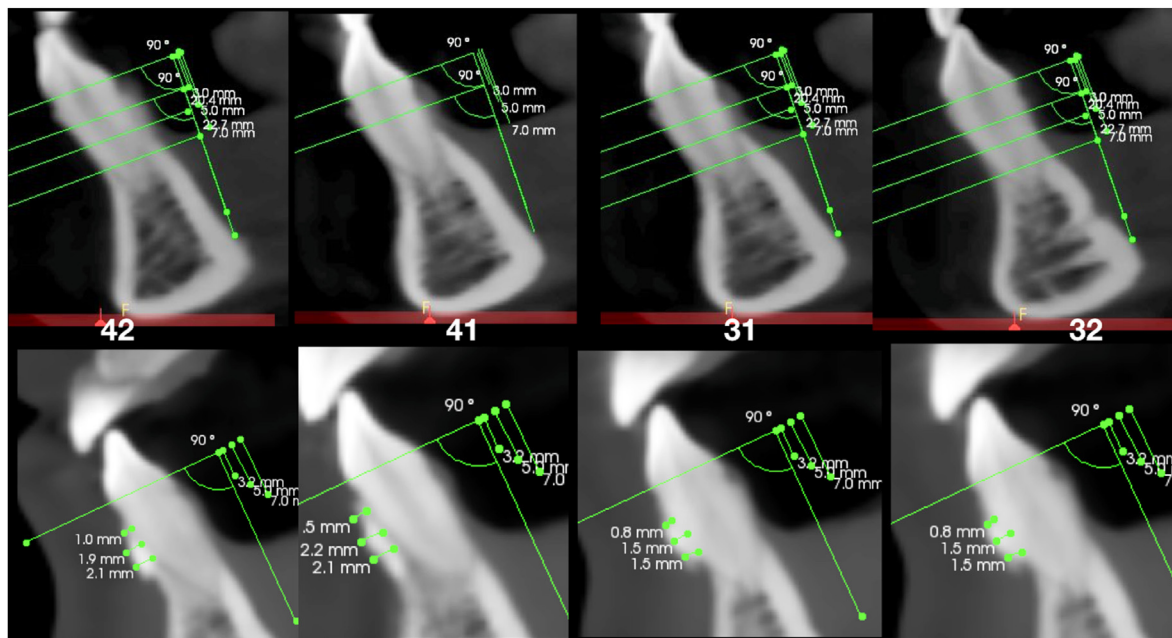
Pre- and post-operative measurements on CBCT sections. Thickness of the buccal plate were measured at 3 different level (3, 5 and 7 mm from CEJ) and compared. See Table 2 for Results.
